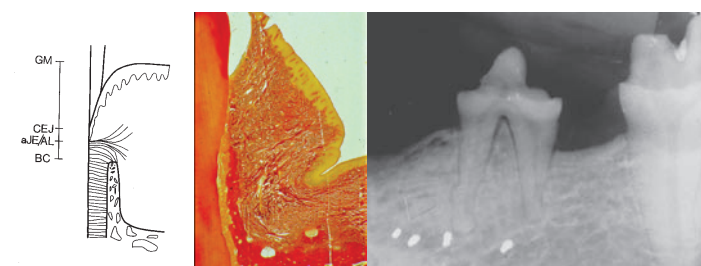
The thin bone on the pressure side of the test tooth was not visualized in the radiograph.
